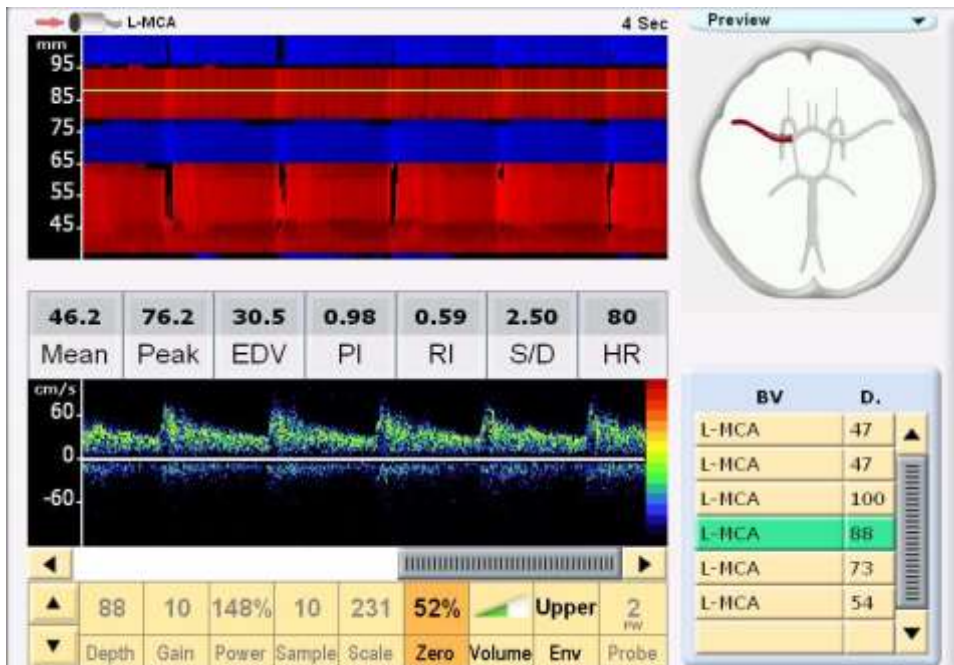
Normal transcranial Doppler using the temporal acoustic window with the screen appearance on SONARA TCD system. Upper frame represents the M-mode signatures from right middle cerebral artery, right A1 ACA and left A1 ACA. Lower frame shows the spectra obtained from a depth of 88mm, showing flow pattern in the contralateral A1 ACA.
